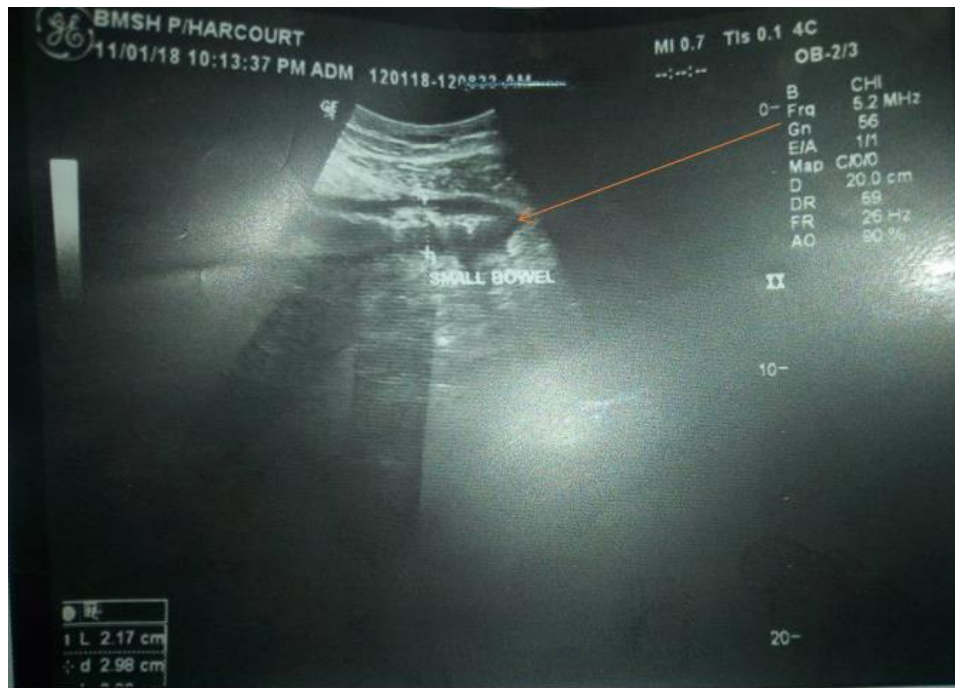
Abdominal ultrasound scan gray scale showing a thick-walled small bowel loop. (Red arrow)
